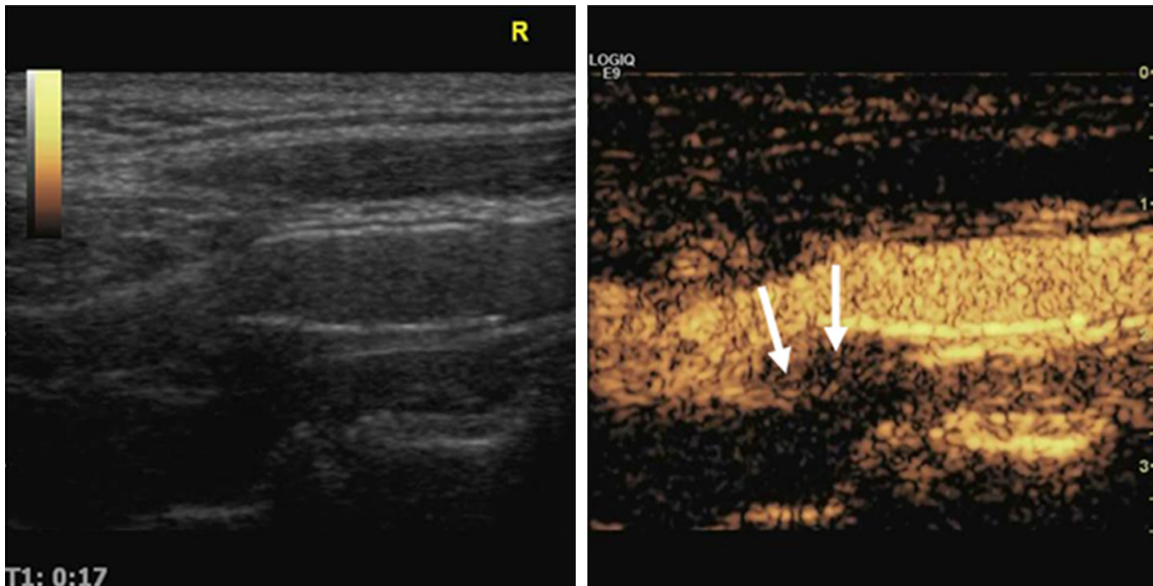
Ultrasound of the left carotid sinus posterior wall revealing low-echo plaque below the stent and the spotty appearance of contrast agent in grade 1 plaque.
